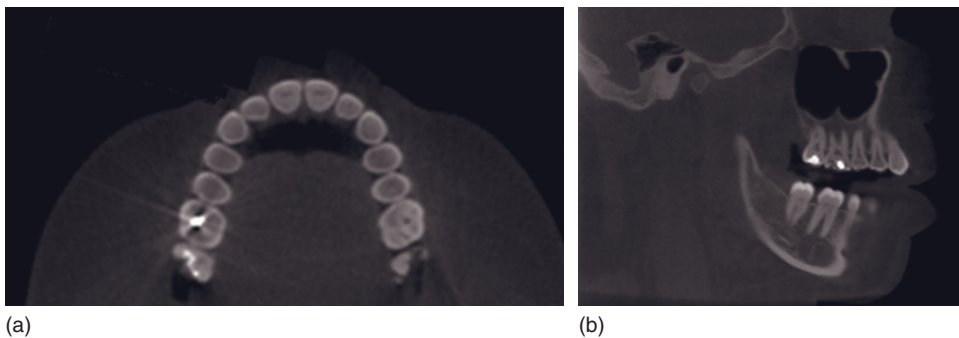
Axial (a) and sagittal (b) sections through the maxillary teeth. The amalgam restorations in the upper right first and second molars cause less severe artifacts than on conventional computed tomography. However, they do cause a radiolucent artifact in the adjacent teeth that can mimic dental caries. (With permission from Imaging Sciences International.)
